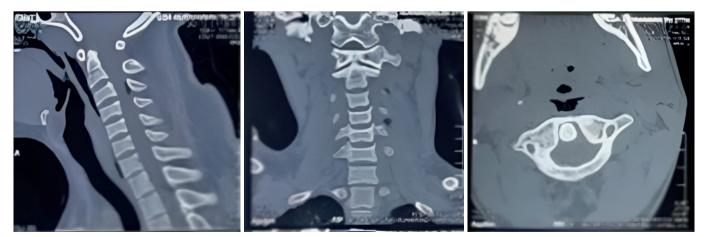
The computed tomography scan results indicated the absence of intracranial hemorrhage and fracture lines, as well as no evidence of cervical corpus fractures or lesions in the longus colli muscle.
